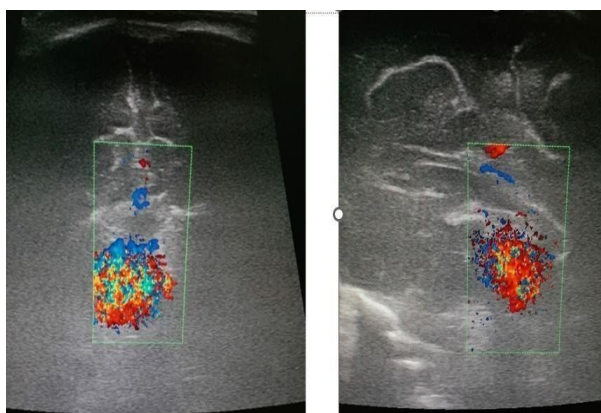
Showing colour aliasing at vein of galen (internal cerebral vein) region with hyperdense focus in that region on plain CT suggesting thrombosis
